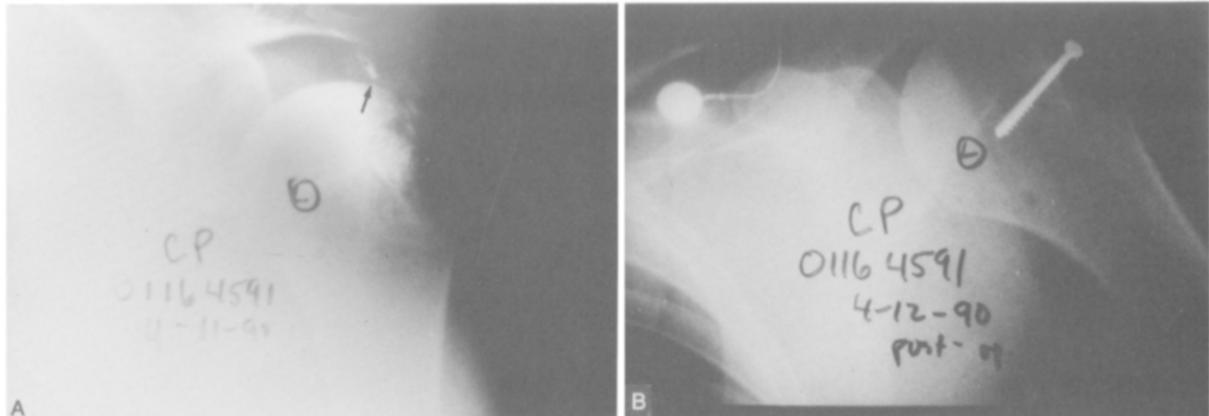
Fifty-year-old man was injured skiing. After closed reduction of dislocation, he was transferred to us. A, Initial anteroposterior radiograph shows comminuted fracture of greater tuberosity with severe superior displacement (*arrow*). B, Anteroposterior radiograph made after surgery. Main fragment was fixed with 4.0 mm cancellous screw, and rotator cuff was repaired. End result was score of 85 points.
